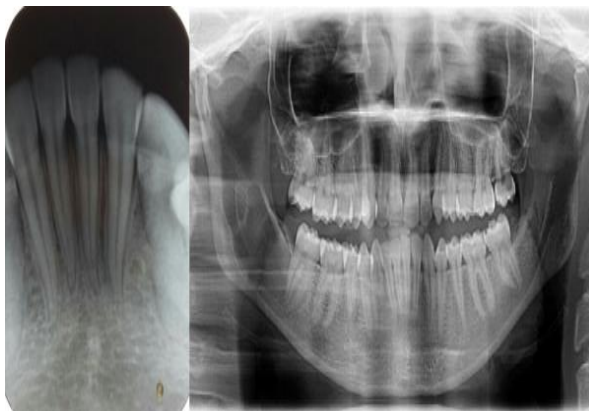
Intraoral Radiographs showing IOPA & OPG
